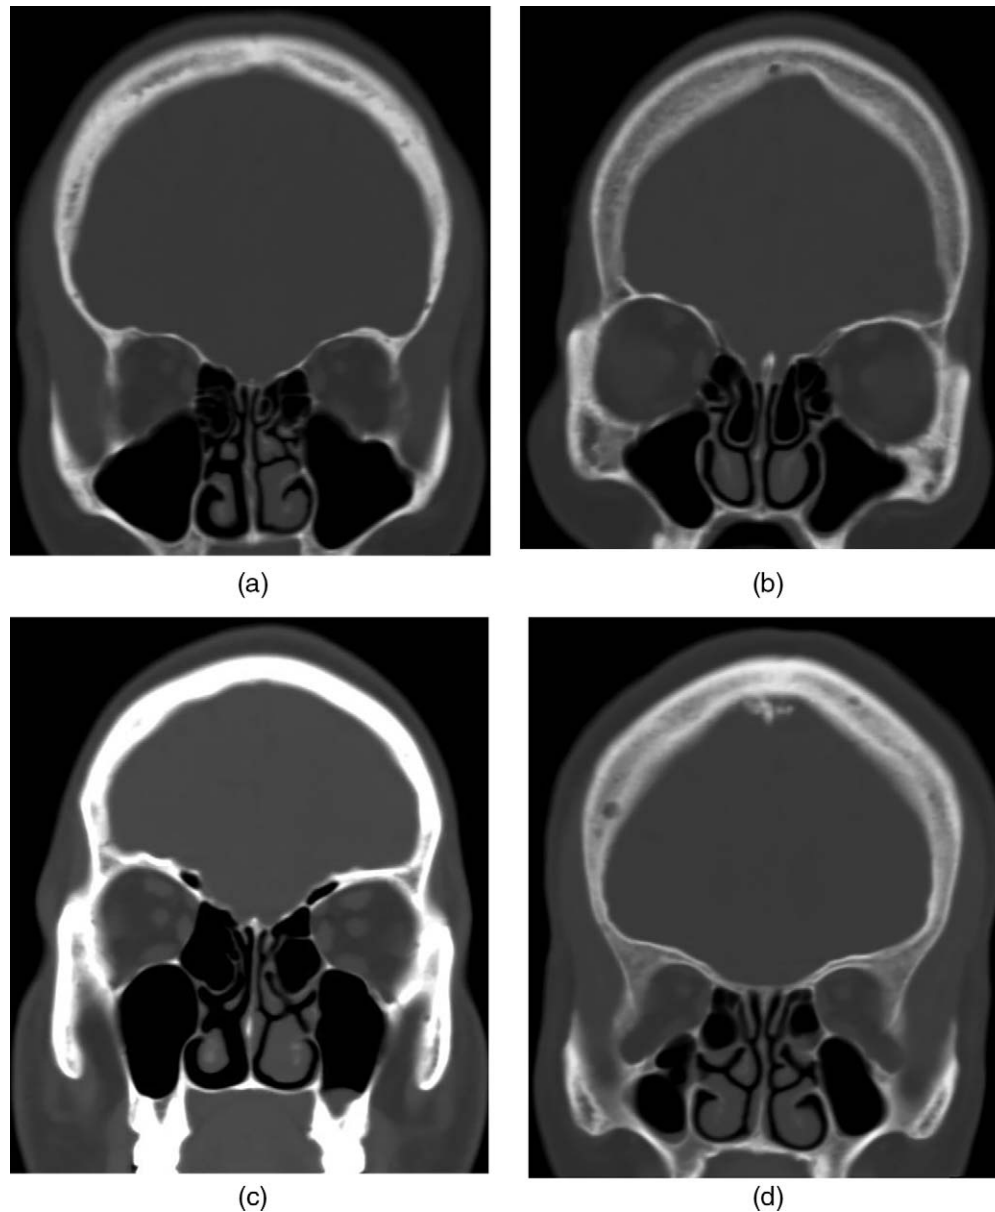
Coronal reformatted CT images showing the different variants of the nasal turbinates. (A) Left superior turbinate pneumatization. (B) Bilateral concha bullosa. (C) Left inferior turbinate hypertrophy. (D) Left paradoxical middle turbinate.
